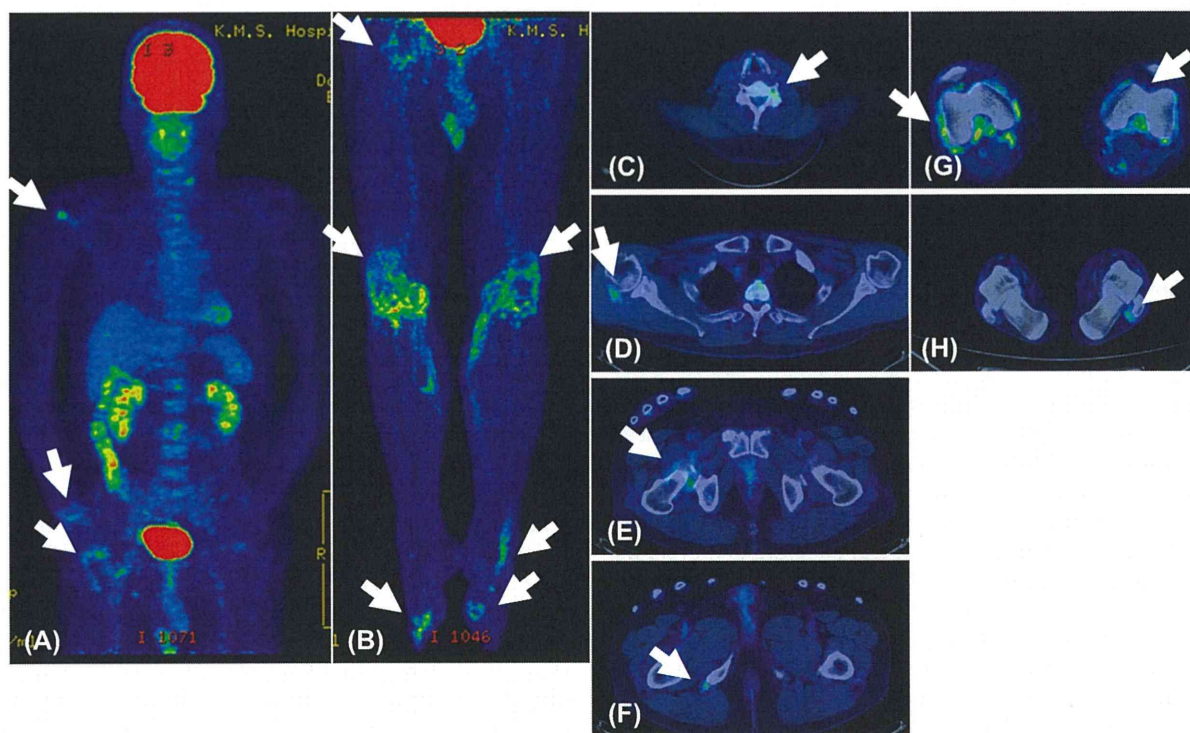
FDG-PET/CT findings of Case 1. Evidence of polyenthesitis and polyarthritis (A and B) was observed in the spinous process (C), shoulder (D), hip (E), ischial tuberosity (F), knee (G) and ankle (H) (arrows).
